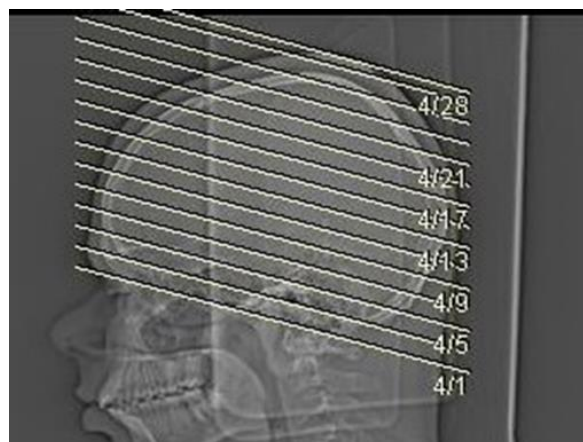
CT images were obtained parallel to orbitomeatal line from foramen magnum to the vertex of the skull 20.
